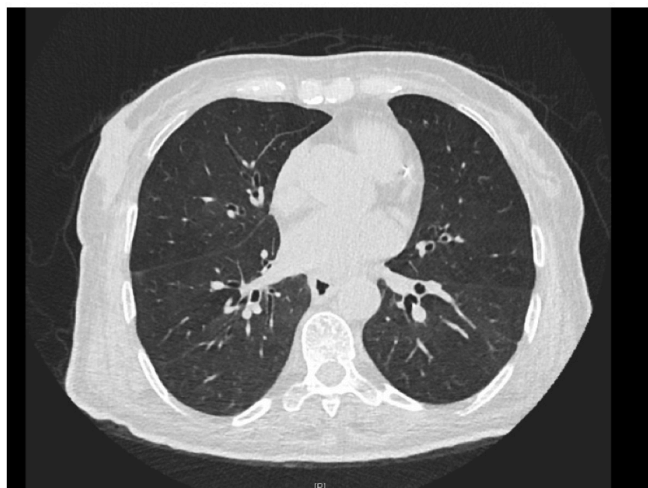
Low dose thoracic CT, dated 28.09.2022.
